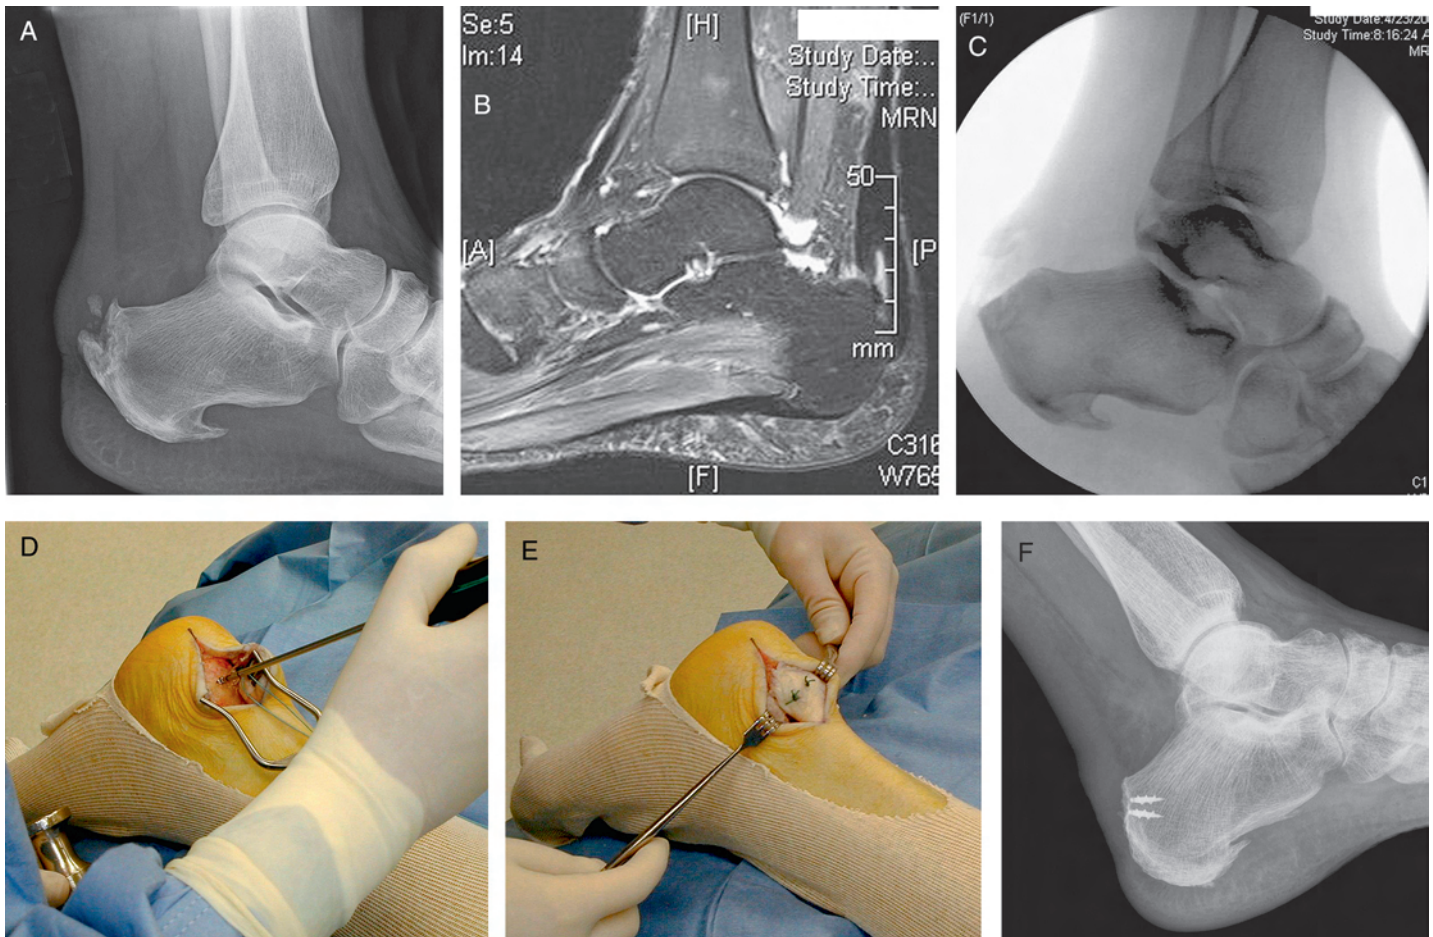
(A) This radiograph reveals that the patient has both an Achilles enthesophyte and a posterior superior prominence of the calcaneus. (B) MRI shows insertional tendinopathy with a small intrasubstance tear of the Achilles tendon. (C) The surgery was performed through a posterior lateral longitudinal approach with detachment of the tendo Achilles. The enthesophyte was resected and the entire posterior superior aspect of the calcaneus was remodeled, shown here in an intraoperative fluoroscopy image. (D) Bone anchors were inserted and (E) the tendo Achilles was reattached, (F) as shown in this postoperative radiograph.
